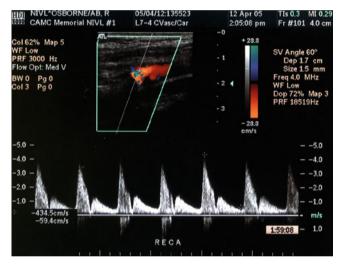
Doppler spectra produced by high-grade stenosis of external carotid arteries. This patient has a peak systolic velocity of 434.5 cm/s. Flow in diastole reaches the zero baseline
